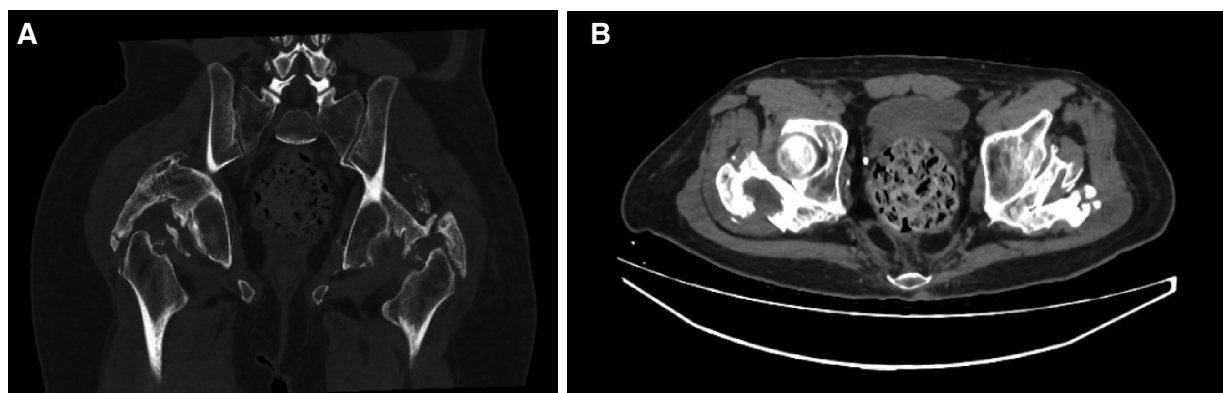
Pelvic and hip CT scan. 2A Coronal plane and 2B Axial plane. In both images, the arrows indicate the presence of heterotopic ossification.
